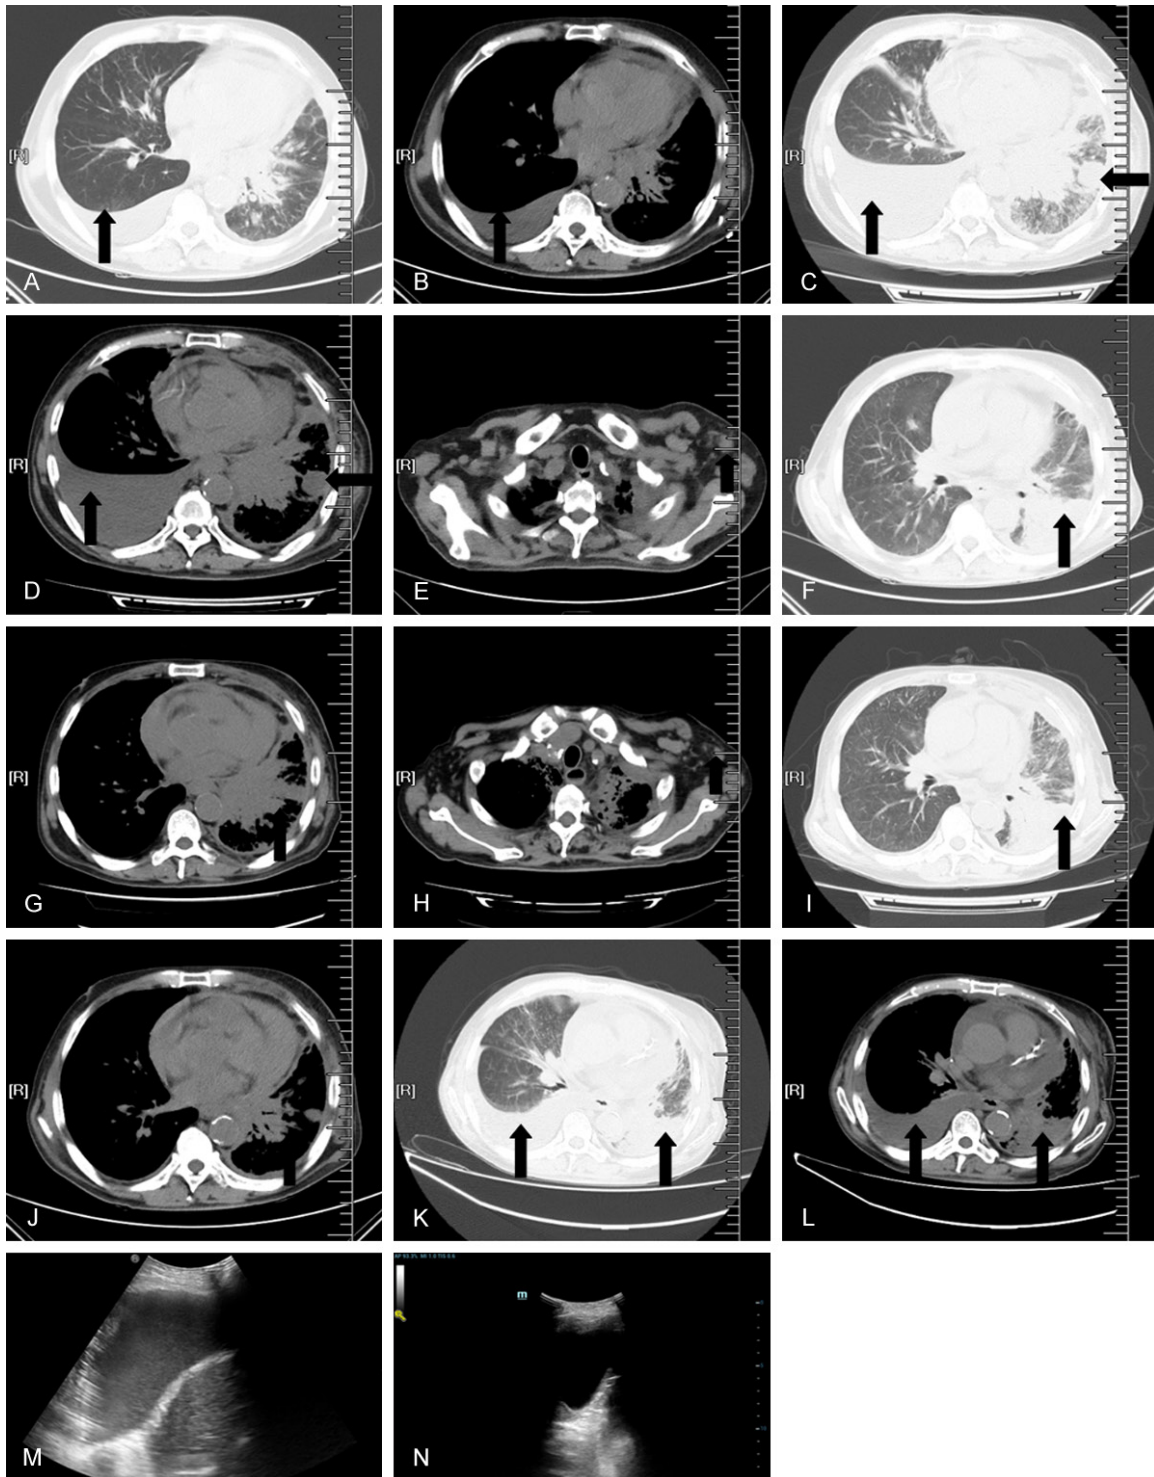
Chest computed tomography (CT). A, B. The chest CT scan reveals pleural effusion of the right mediastinal window before icotinib treatment on August 24, 2016; C, D. CT showed that bilateral pleural effusions was significantly progressed more than before and pulmonary nodules were similar to previous readings after icotinib treatment for 17 days on September 10, 2016; E-L. Shows the left axillary lymph nodes, pericardial effusion, pleural effusion and pulmonary nodules. E-G. Chest CT indicated that pulmonary nodules, bilateral pleural effusion, the left axillary lymph node and pleural effusion before apatinib treatment on September 27, 2016; H-J. CT shows that the left axillary lymph node was smaller than before, pericardial effusion was less than before, but pleural effusion and pulmonary nodules were stable after apatinib treatment for 4 days on October 7, 2016; K, L. Apatinib treatment for 52 days (November 25, 2016), the pleural effusion of the right appeared again and the pleural effusion of the left increased more than before (October 7, 2016). The patient PFS has increased to 52 days after taking apatinib. M.
